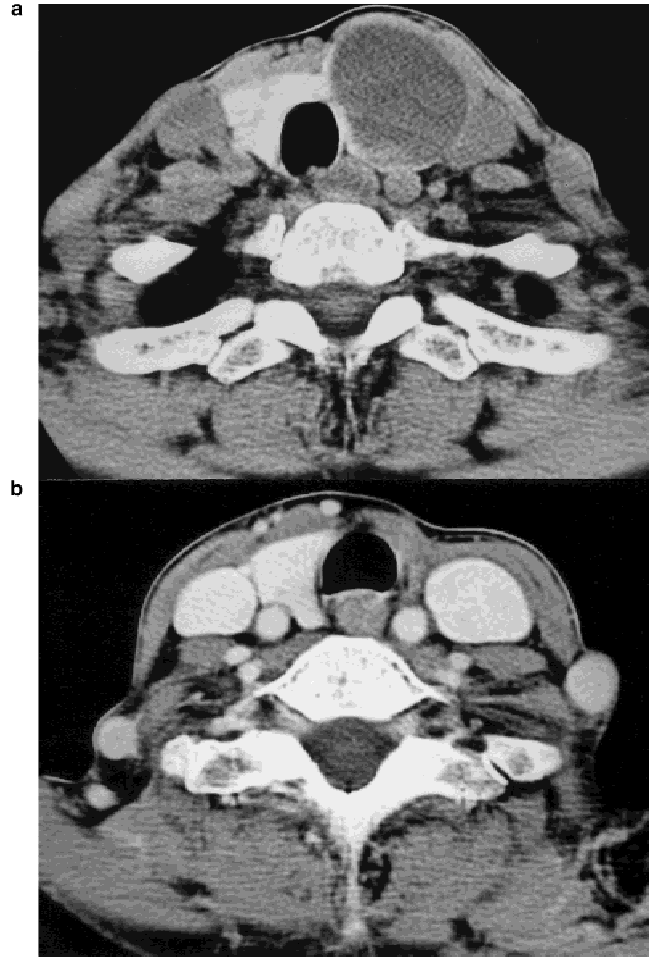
Preoperative (a) and postoperative (b) neck computed tomogram in patient with nodular goiter.
